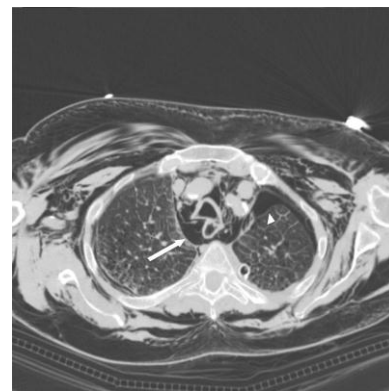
CT scan. Same patient of figure 11 observed in a more cranial CT slice.
